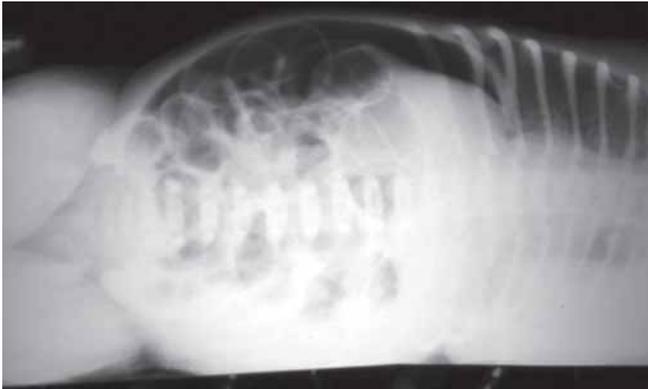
Free gas seen on lateral decubitus X-ray
